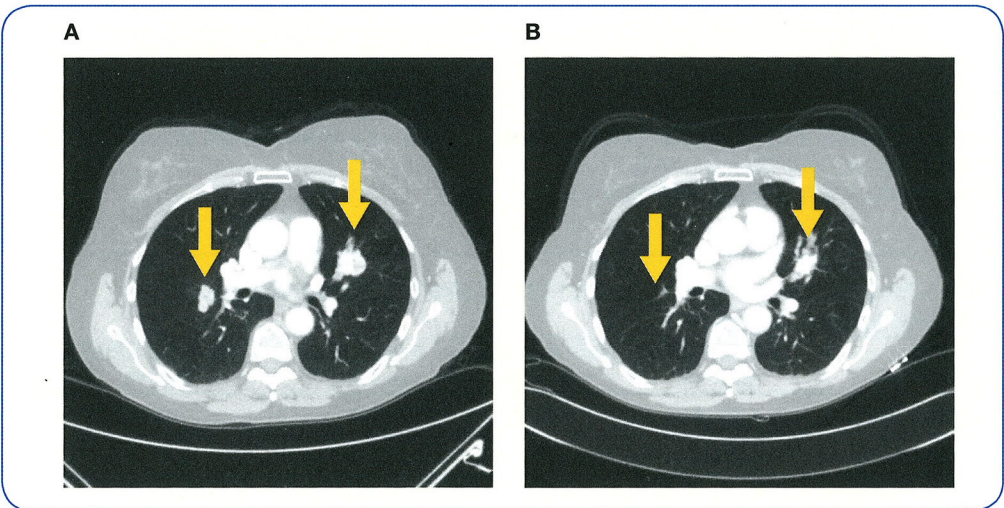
Computed tomography scans of patient 16 at baseline (panel A) and cycle 23 (panel B).
